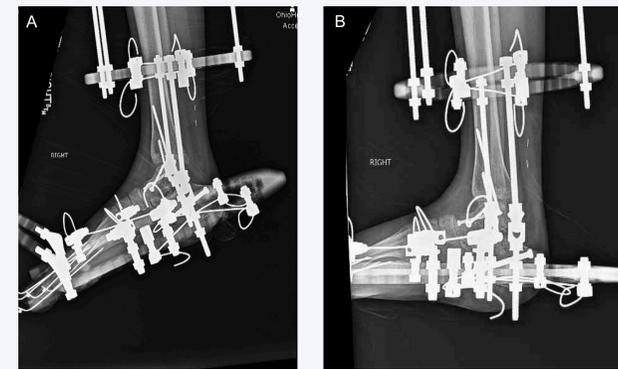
Serial postoperative radiographic progression. Note the significant improvement in dorsiflexion at the ankle. A) 6-week postoperative lateral radiograph. B) 13-week postoperative lateral radiograph.
